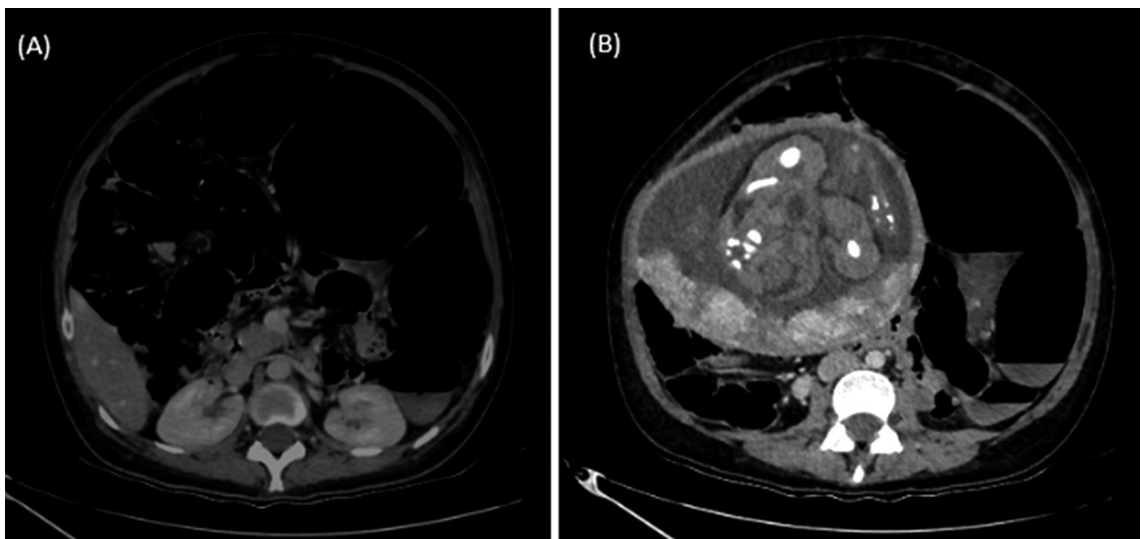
Contrast-enhanced computed tomography of the abdomen and pelvis. (A) Transverse section at the level of the kidneys. (B) Transverse section at the pelvic level, showing a gravid uterus with an intrauterine fetus.
